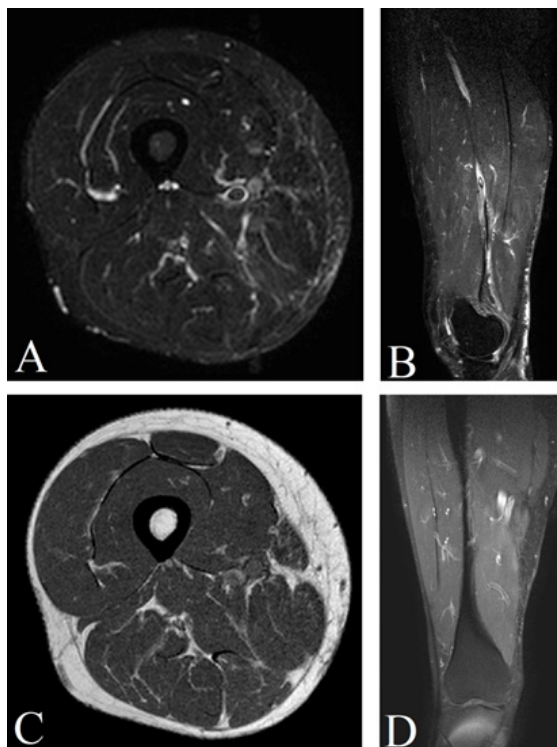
T2 STIR MRI in axial (A), and sagittal (B) sections, T1 axial section (C), and T1 SPIR with contrast coronal section demonstrating a normal thigh after appropriate treatment.
